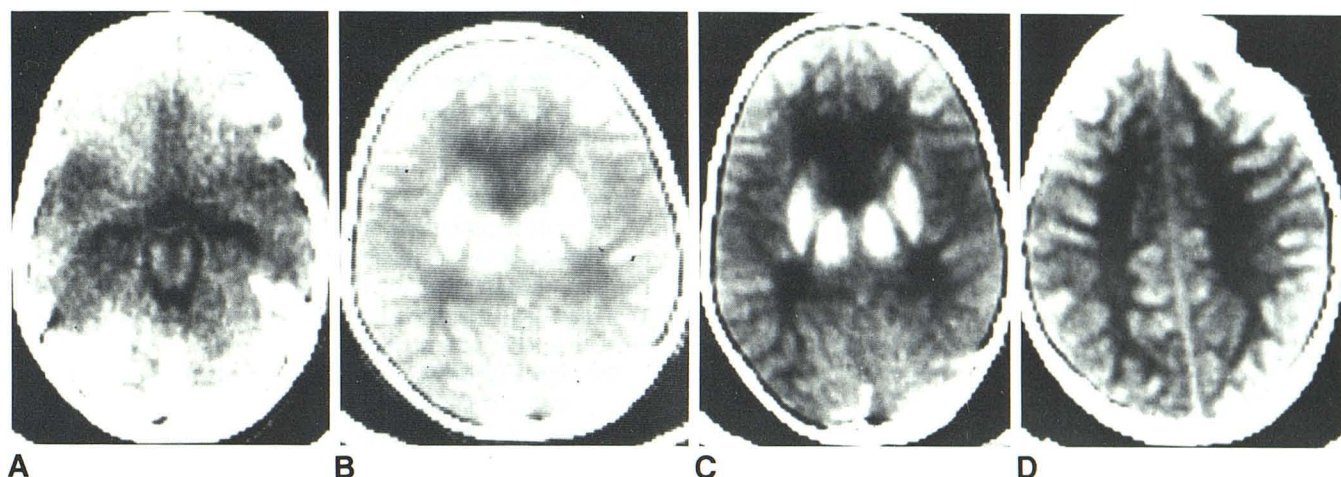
Postmortem CT scan performed approximately 48 hr after the administration of contrast material. The appearance is nearly identical to a scan made at 22 hr, but contains less artifact. A, Level 65 H, window 75 H; the circle of Willis and anterior, middle, and posterior cerebral arteries are filled with contrast medium. B, The level of central gray structures, displayed at the usual
